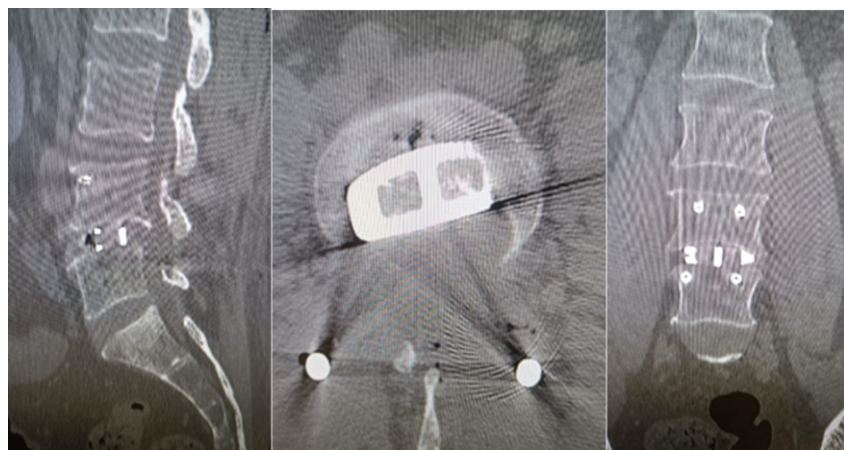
Final post-operative computed tomography lumbosacral spine with large footprint cage.
